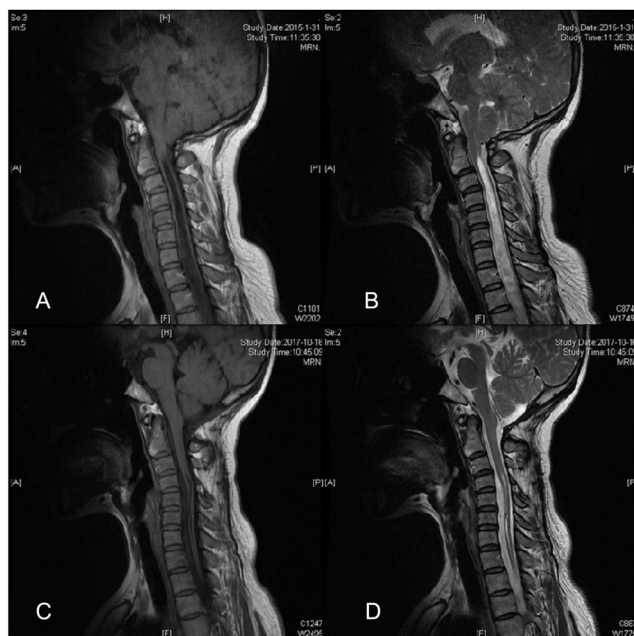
MRI of Chiari malformation type I. (A) and (B) Cerebellar atrophy and cerebellar ptosis after improper PFD. The ODA was an acute angle and the outlet of the fourth ventricle located below vertex of ODA. (C) After occipital bone repair, atlas posterior arch excision and duraplasty, ODA was increased, hernia and ptosis were recoiled, and syringomyelia became obviously smaller.
